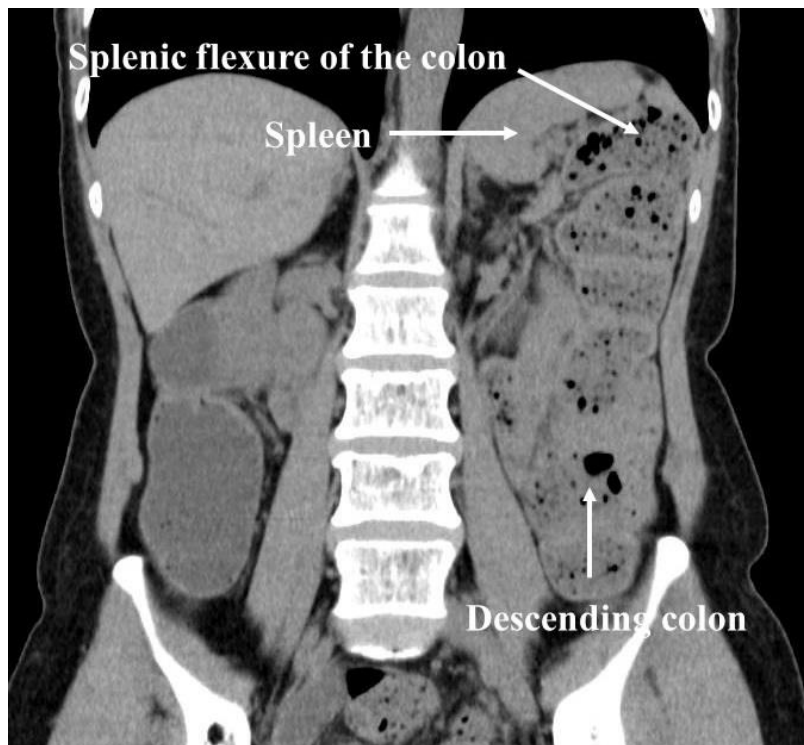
Preoperative CT scan revealed that splenic flexure of the colon was located on the top of left diaphragm dome. The splenic flexure of the colon was located on the left side of the spleen and closely adjacent to the diaphragm (Figure 2).
